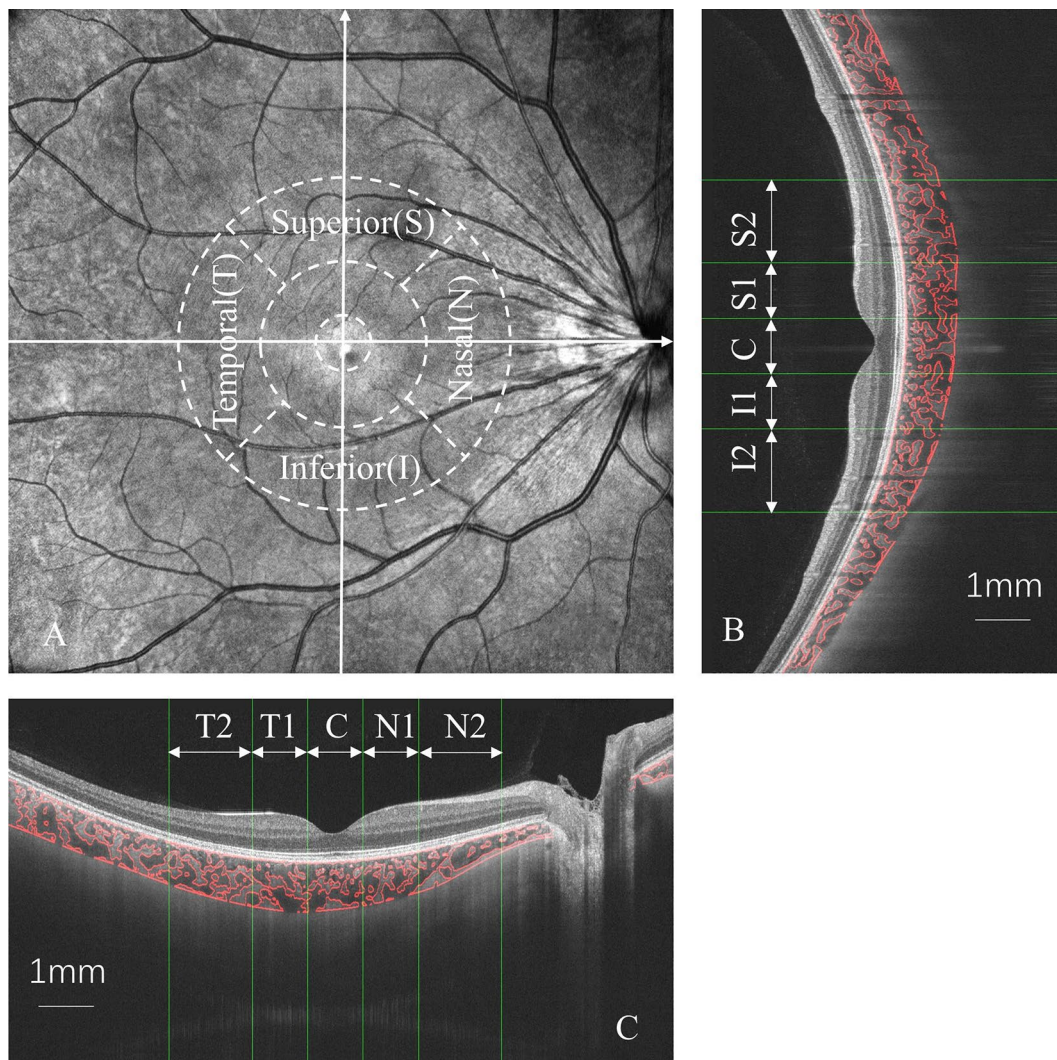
Choroidal vascularity index (CVI) and choroidal thickness (CT) were measured in macular zone according to ETDRS grid (A). Both vertical (B) and horizontal (C) scans were measured using semi-automatic algorithms in MATLAB R2017a. T1, temporal parafovea; T2, temporal perifovea; N1, nasal parafovea; N2, nasal perifovea; I1, inferior parafovea; I2, inferior perifovea; S1, superior parafovea; S2, superior perifovea; C, center
